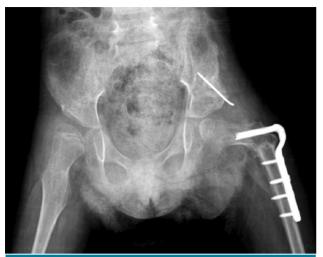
Anteroposterior pelvic radiograph of patient at 12th postoperative week.
